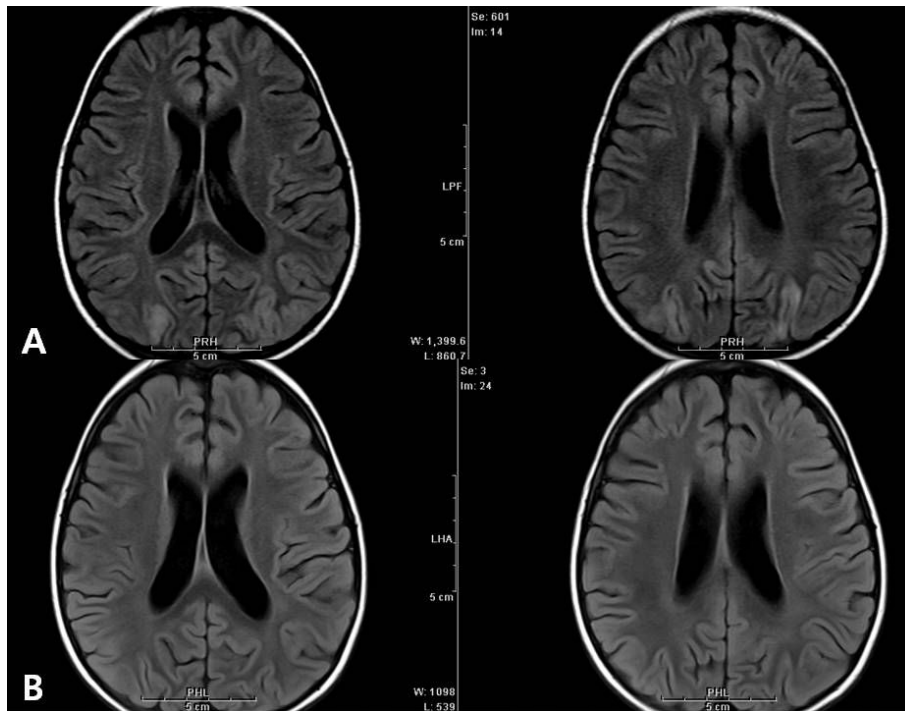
Initial magnetic resonance imaging (MRI) scans (A) and follow-up MRI scans (B). The initial MRI scan shows multifocal cortical lesions on both sides of the temporoparietooccipital lobe. The follow-up MRI scan did not show the cortical lesions that were previously observed on the temporoparietooccipital lobe.
